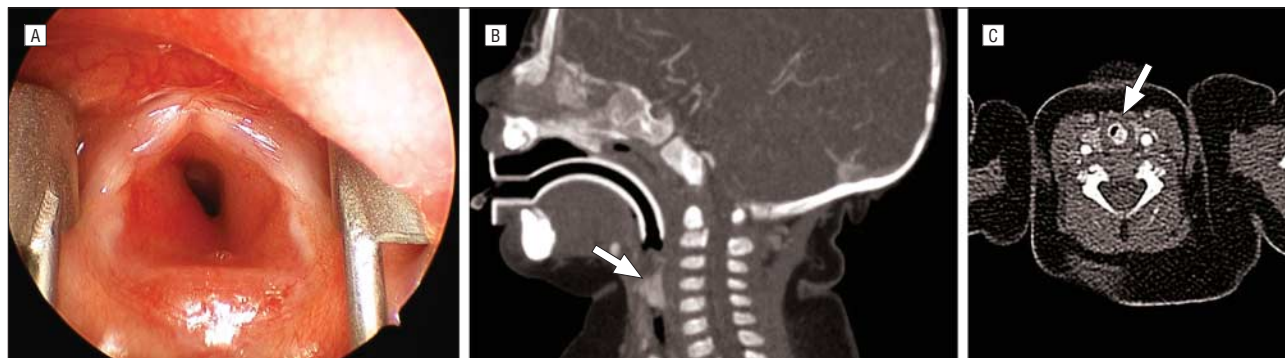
Posterior lateral airway infantile hemangioma. A, Endoscopic view of a posterior lateral airway infantile hemangioma. B, Sagittal computed tomographic angiogram demonstrating an enhancing mass extending from posterior to anterior (arrow). C, Axial computed tomographic angiogram demonstrating an enhancing mass in the posterolateral position (arrow).
